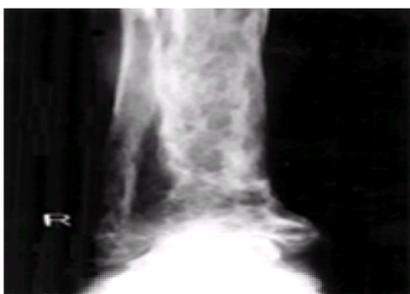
A radiograph of the right lower leg of a patient with Paget's disease. Just above the ankle joint the markedly lytic region contains an osteosarcoma.
